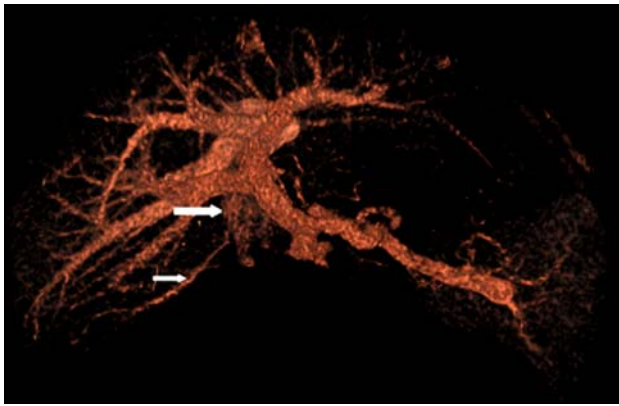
3D reconstruction of spiral CT showing inferior right hepatic vein
